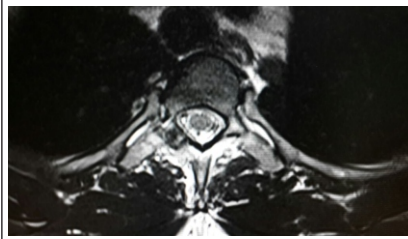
the same lesion appears hypointense in T2W axial cut MRI.
